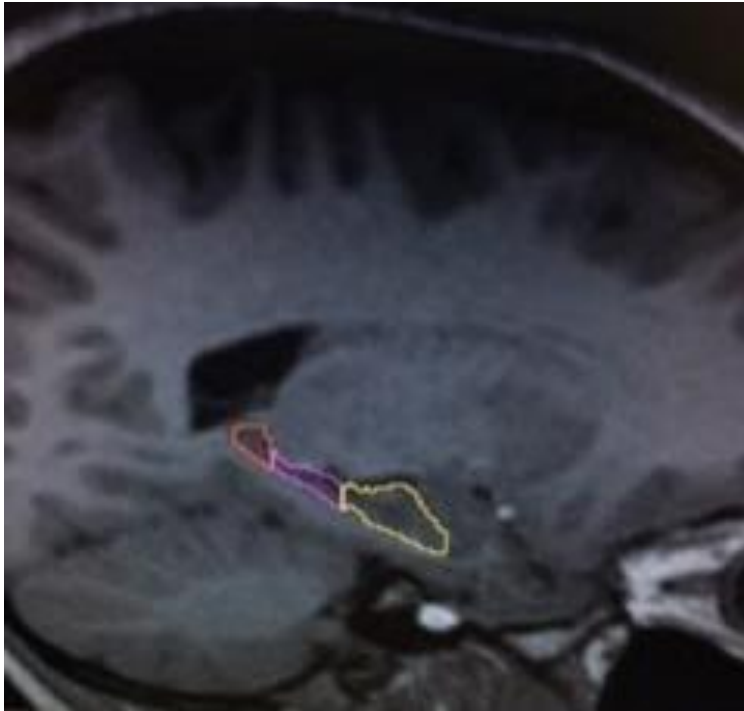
Verification of alignment; MRI scan; sagittal view
